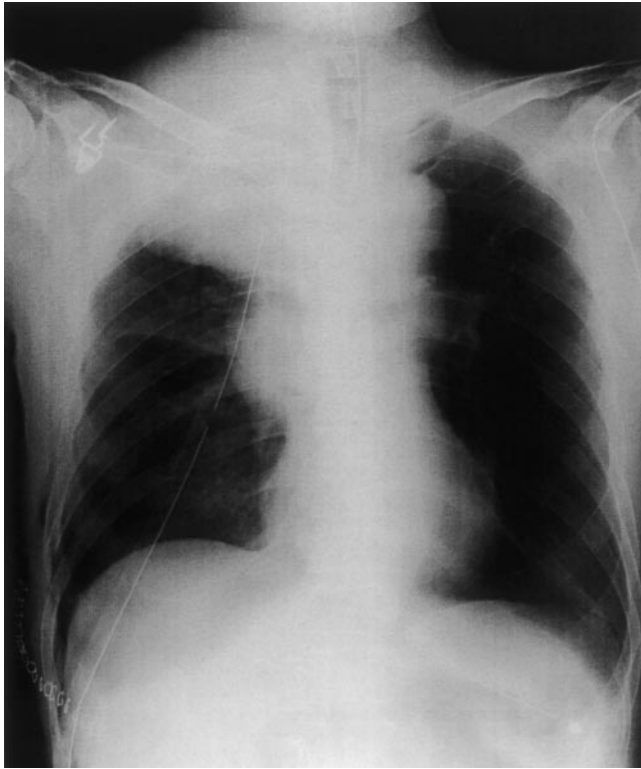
Chest radiograph in the recovery room. Chest radiograph showed bulging of the upper-right mediastinum.
